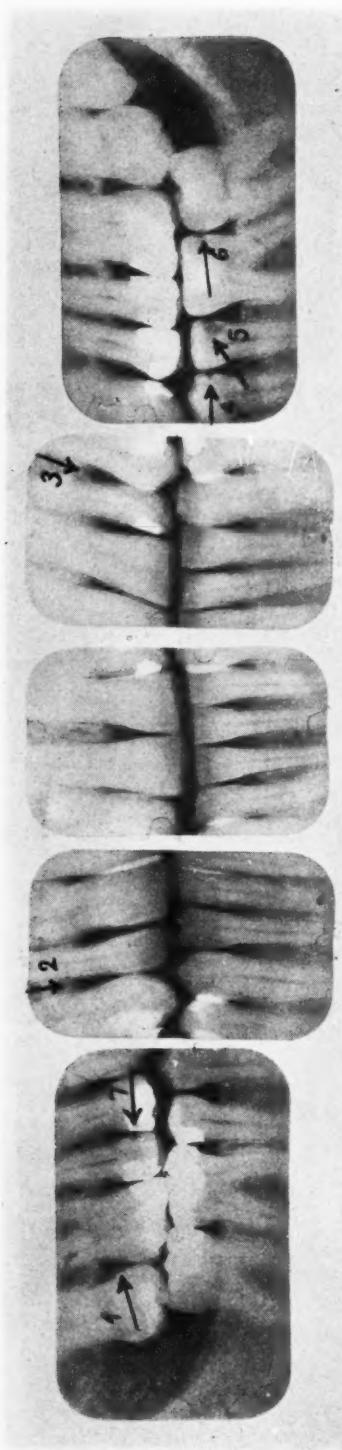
Arrow 1 points to a small bit of calculus on the mesial of the maxillary second molar. Arrows 2 and 3 point to incipient pyorrhoid. Arrows 4, 5 and 7 point to carious cavities. The cavity indicated by Arrow 5 is getting rather large, having destroyed considerable dentine; immediate filling is indicated. The cavities indicated by Arrows 4, 6 and 7 have just nicked the enamel; they should be kept under periodic radiographic observation.
